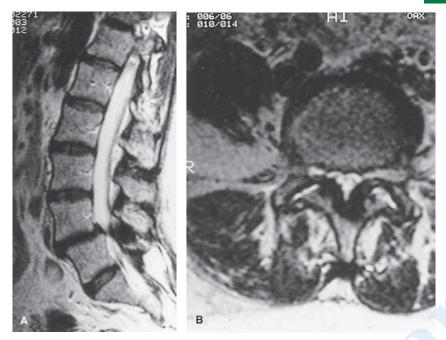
A: T1-weighted sagittal MRI shows a lumbar disc extrusion at L5–S1 that has gone down the lumbosacral canal (*arrow*). B: T2-weighted axial MRI shows a large, extruded L5–S1 disc fragment (*solid arrow*) compressing the right S1 nerve-root (*open arrow*).
